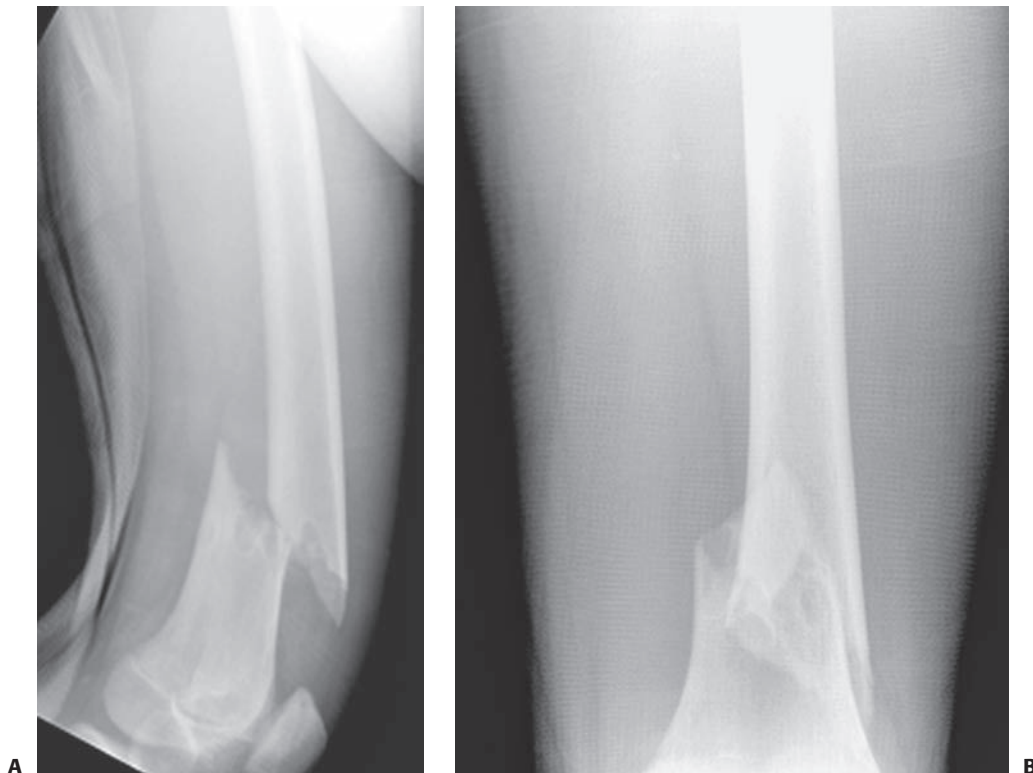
AP (A) and lateral (B) radiographs a low-energy short oblique fracture through a fibrous cortical defect in the distal femur; this type of fracture is not unusual. The surgeon judged that there was enough distance between the fracture site and the growth plate to allow external fixation.
